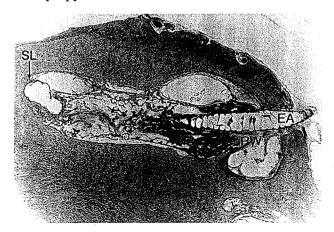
Basal turn near cochleostomy site of case 8, in which there was no radiographic or clinical evidence of new bone formation before operation (original ×15). Electrode array (EA) can be seen entering cochlea near round window (RW). There is new bone (NB) in scala tympani. Basilar membrane of basal turn is displaced, and trauma to spiral ligament (SL) is apparent.
